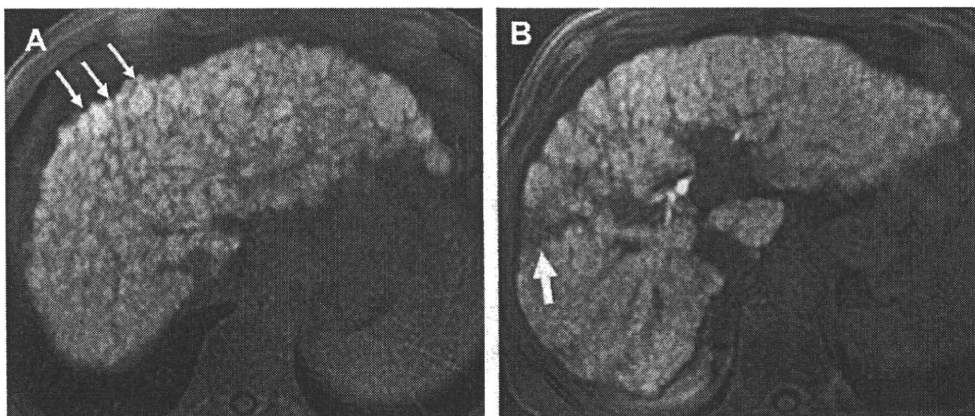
T1-weighted fat-saturated 3D GRE image (TR/TE = 3.6/1.7 ms, flip angle = 15°) after administration of Gd-EOB-DTPA at hepatocyte-selective phases also clearly demonstrates fibrotic reticulations (A) and confluent fibrosis (B = wedge shape) (arrows).
